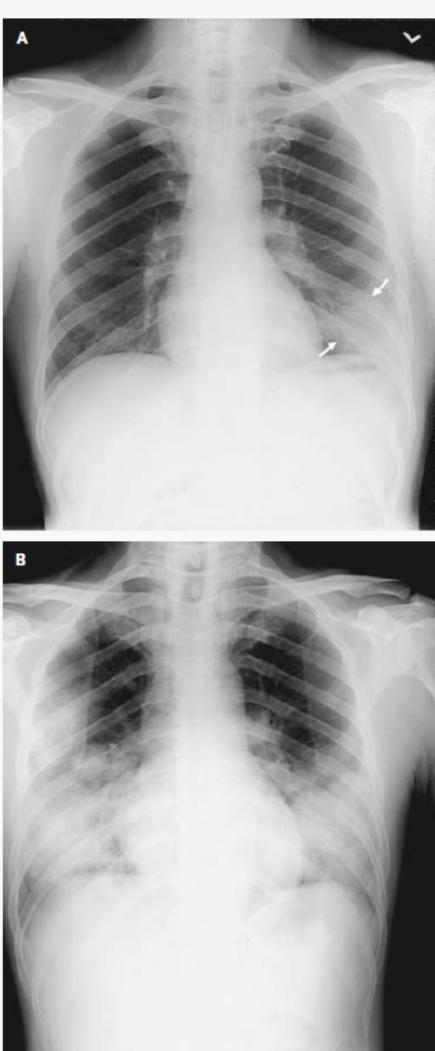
Frontal Chest Radiographs in a 46-Year-Old Man.
